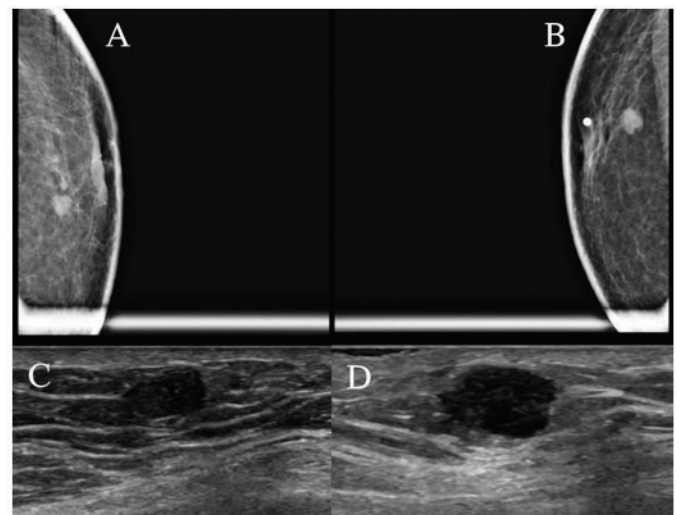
Bilateral breast diagnostic mammogram and ultrasound. (A) Left breast cranial caudal view. (B) Right breast cranial caudal view. (C) Left breast ultrasound with a $0.7 \times 0.4 \times 0.7$ cm hypoechoic mass at the 8 o'clock retroareolar region. (D) Right breast ultrasound with a $0.8 \times 0.5 \times 0.9$ cm hypoechoic mass at the 7 o'clock retroareolar region.
